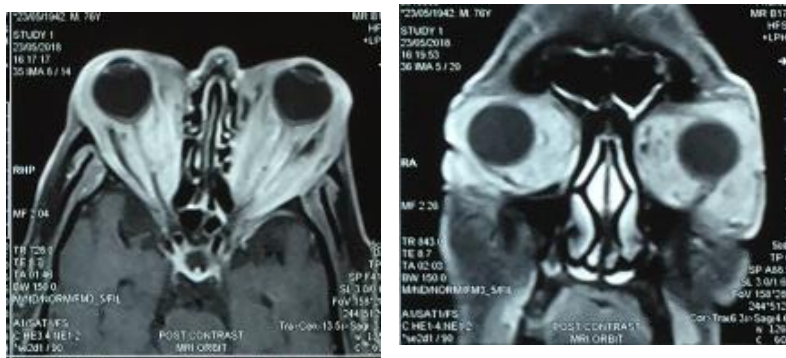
a and b) MRI On T1 Axial and coronal with contrast shows heterogenous diffuse hypertrophy of extra ocular muscles with tendinous insertions.
